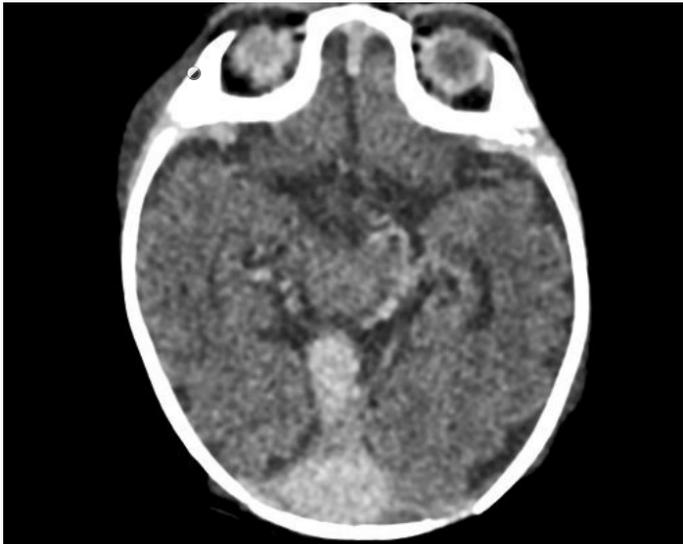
VGAM in MRI Brain
